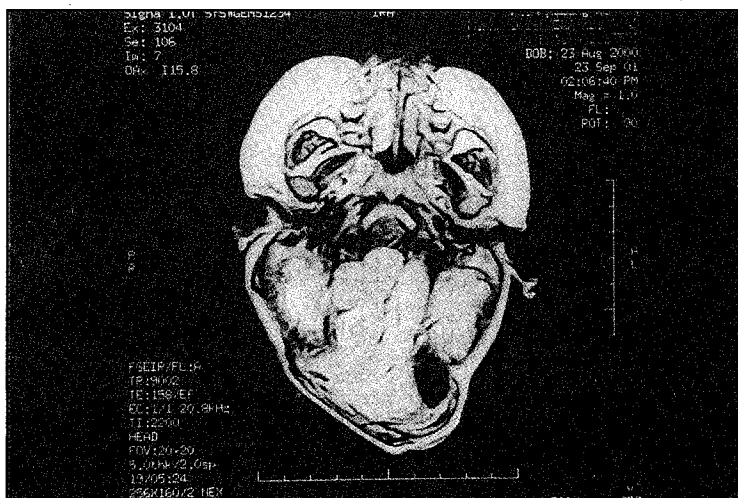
Axial MRI FSEIR showing the successful draining of CSF following shunt catheter insertion.
